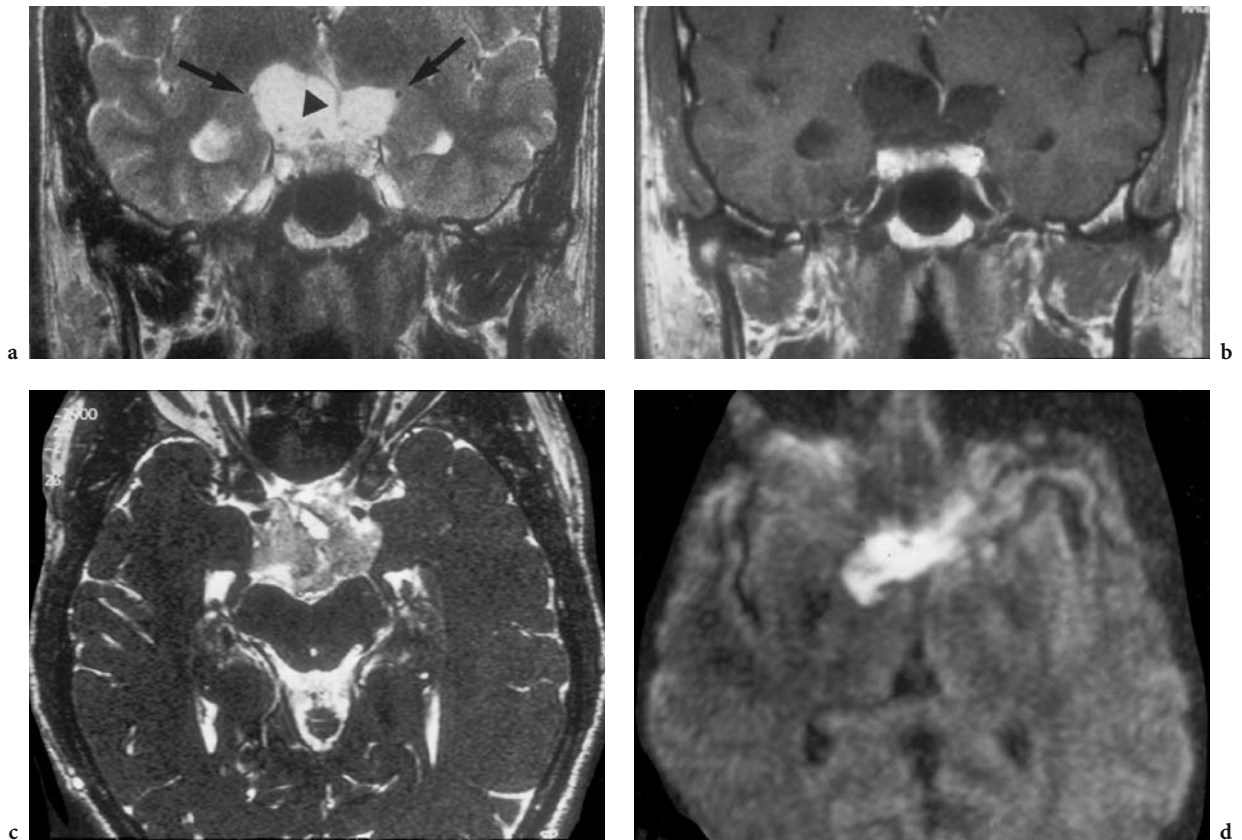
A 30-year-old man with atrophy of the right optic nerve and slowly progressing visual field deficit. Diagnosis: suprasellar epidermoid. MRI: a Coronal T2-weighted view demonstrating a hyperintense suprasellar mass, displacing the vessels (*arrows*) and the pituitary stalk seen paramedian (*arrowhead*). b Corresponding T1-weighted, contrast-enhanced view, showing no enhancement of the lesion but the proximal pituitary stalk. c Axial T2-weighted view with intermediate signal enhancement of the irregular mass. d Axial diffusion-weighted image, the signal enhancement proves the suspected epidermoid. (a, b with permission of the colleagues of Radiologische Praxis, Alzey)
